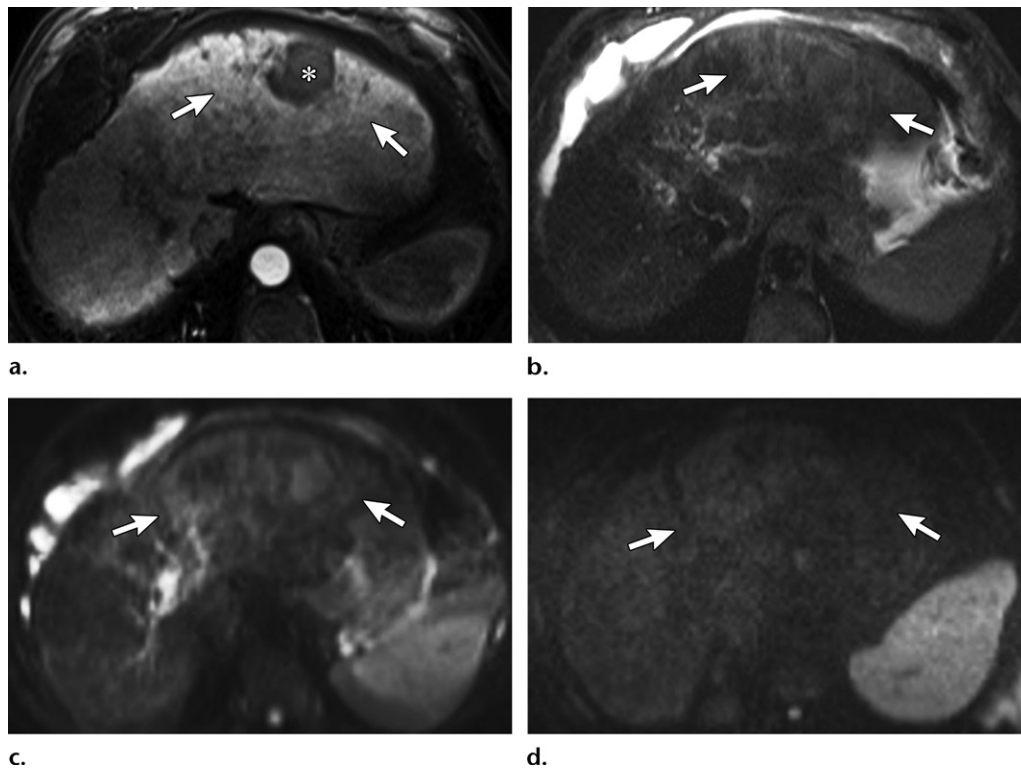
Post-TARE inflammatory changes in a 66-year-old man with HCC. (a) Axial posttreatment arterial phase MR image shows ill-defined areas of perilesional parenchymal enhancement (arrows). * = tumor. (b, c) Axial T2-weighted fat-saturated (b) and diffusion-weighted ($b = 50 \text{ sec/mm}^2$) (c) MR images show mildly high signal intensity in the treated nontumoral areas (arrows). (d) Axial diffusion-weighted ($b = 800 \text{ sec/mm}^2$) image shows complete attenuation of the signal, which is isointense to the background parenchyma (arrows). These findings favor benign changes.
